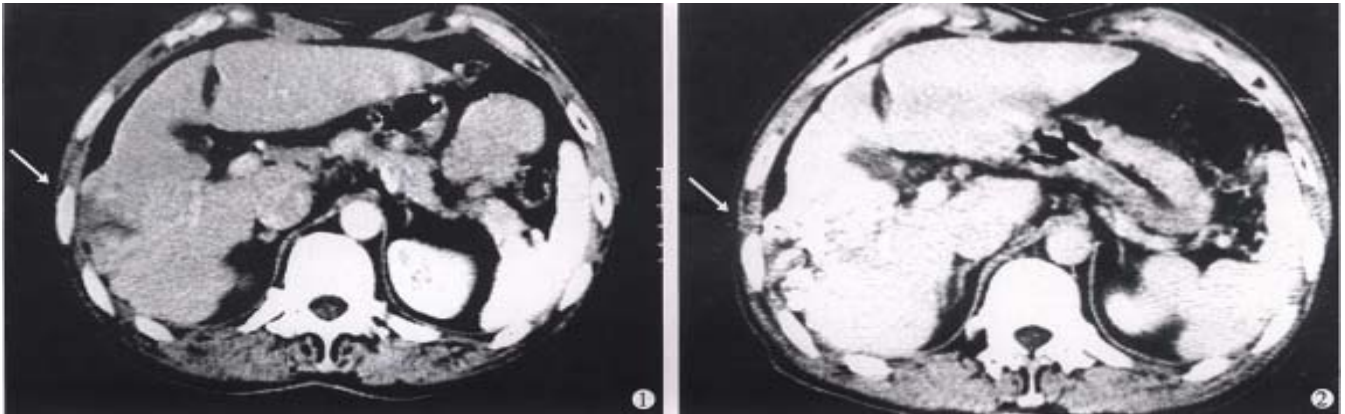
Male, aged 60, hospital no.202929, clinical diagnosis: right lobe medium sized hepatic carcinoma (4cm×5cm), treated by regimen A and B with an interval of 2 months. AFP from 103μg/L restored to normal range, tumor size decreased >50%, CT: 1, on pre-treatment showing a low density region in right lobe (arrow), 2, on post-treatment iodized oil distributed in fragments or encapsulated forms (arrow). Body weight gained more than 5kg and no subjective symptoms on 36 months follow-up.
